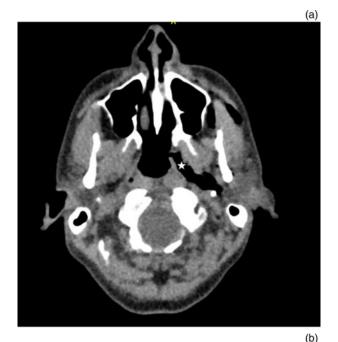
(a) Axial computed tomography (CT) scan showing extensive surgical emphysema and a tract following the lateral pharyngeal wall (see star). (b) Coronal CT scan (reconstructed in a plane parallel to Eustachian tuboplasty) showing the passage of the airway from the site of Eustachian tuboplasty to the neck (indicated by arrow).
